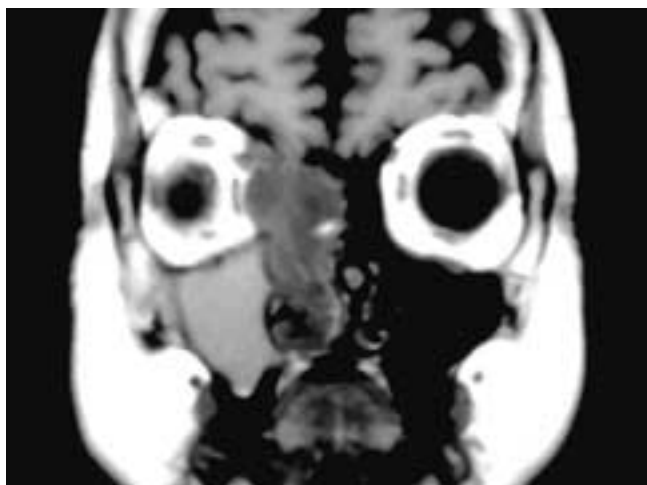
Coronal T1-weighted MR image shows a low signal intensity mass in the right ethmoid complex and nasal fossa. The tumor has broken into the right orbit, but the tumor interface with the orbital fat is smooth and not infiltrative. The right maxillary sinus is chronically obstructed with intermediate signal intensity secretions. This patient had a melanoma.
